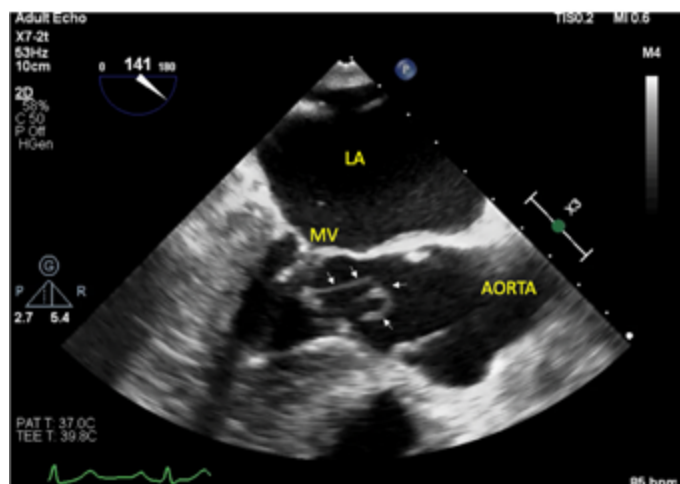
Accessory mitral valve tissue (white arrows) extending to the left ventricular outflow tract in transesophageal echocardiography midesophageal long axis view (LA, Left Atrium; MV, Mitral Valve).
